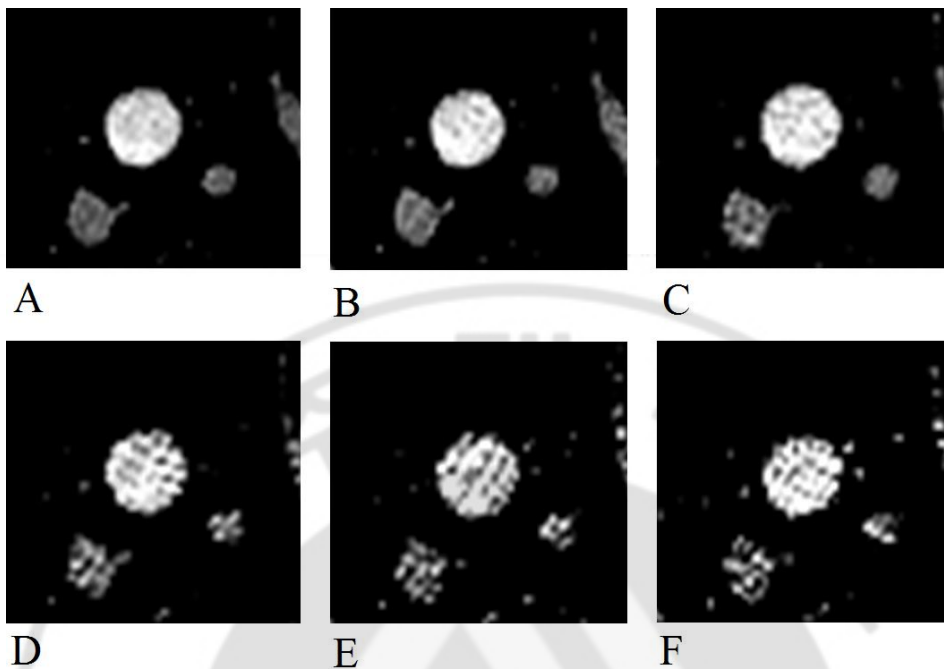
CT images of nodule 9 in various tube parameters obtained using 128-detector-row scanner. Note increasing image noise with low tube current. (Window width/level = 350/40)
